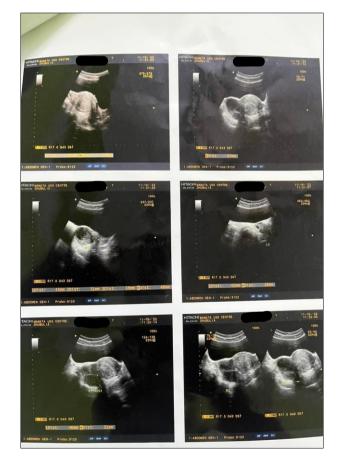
Ultrasonographic report before treatment
